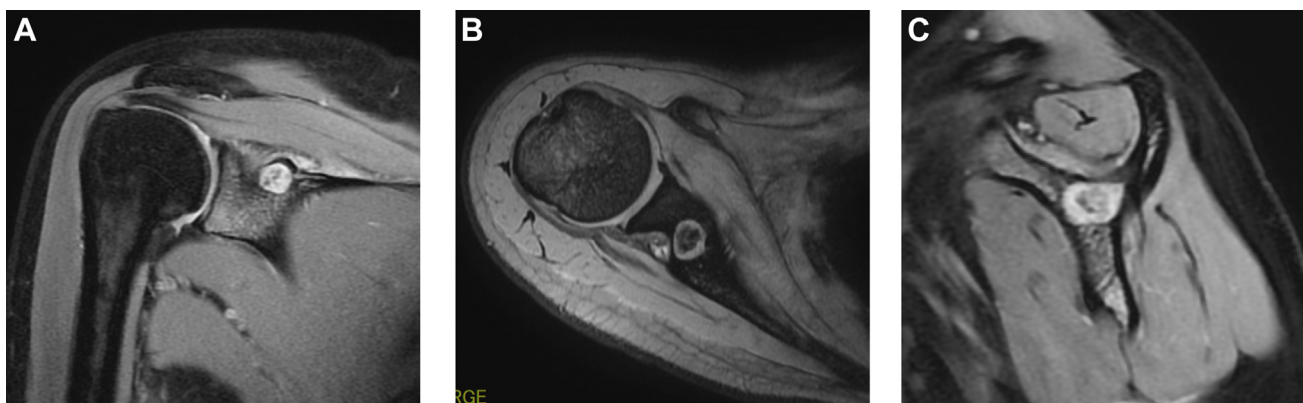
MRI: (A), PD fatsat Coronal view; (B), T2* Axial view; and (C), PD fatsat Y view. PD fatsat showed a circular, marginally high signal around the tumor and a low-signal tumor (nidus) inside it. MRI, magnetic resonance imaging; PD, proton density.
